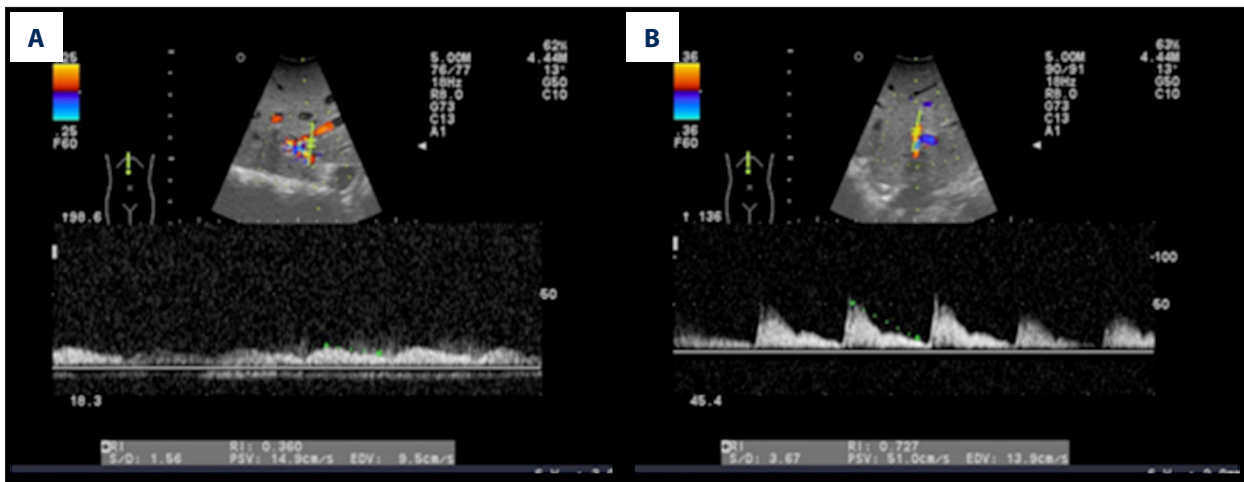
Ultrasonography performed for a 6-year-old child using Aloka α 7 during liver transplantation. (A) Hepatic artery spasm and ramus communicans arteriae were displayed on spectral Doppler; (B) Hepatic artery blood flow spectrum returned to normal after relieving spasm by immersing in lidocaine.
